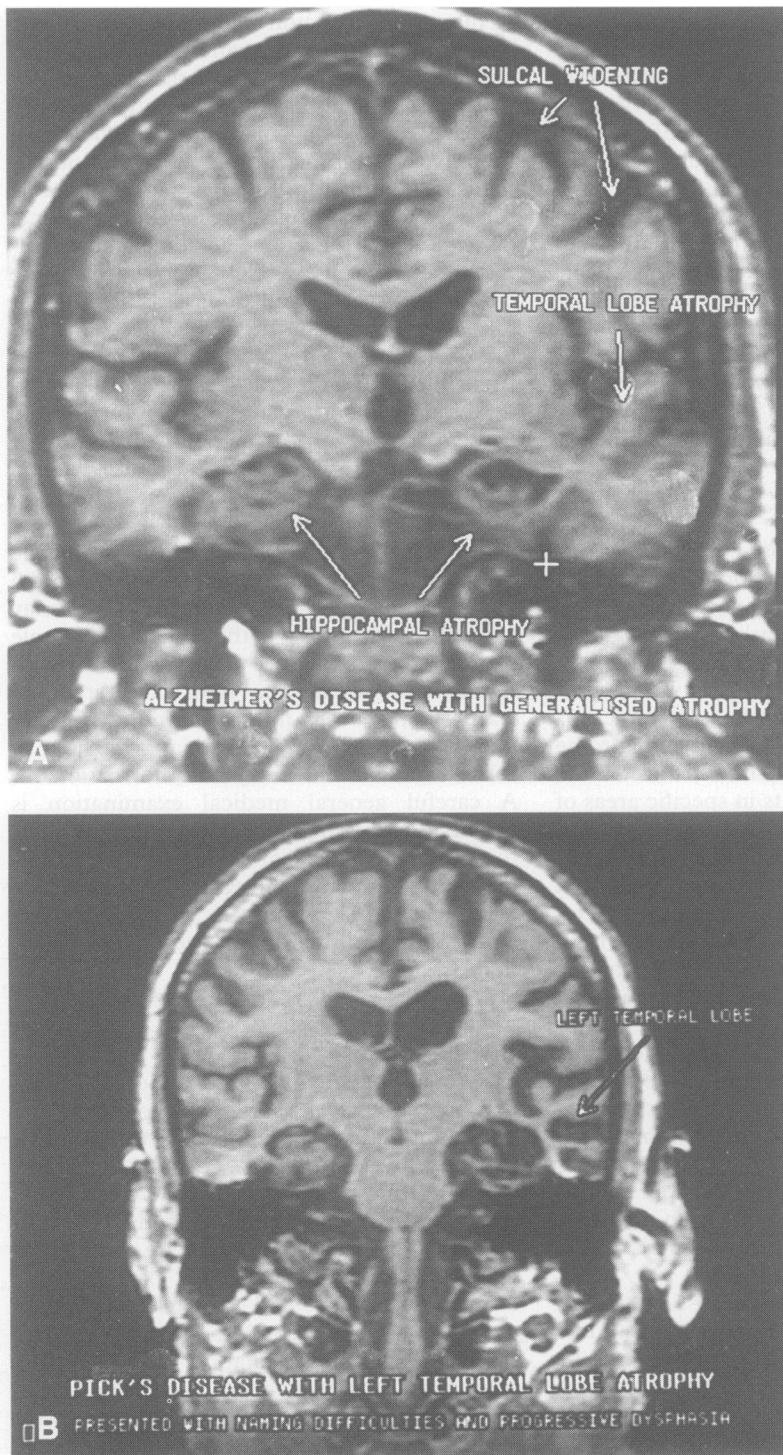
(A) MRI showing bilateral hippocampal and temporal lobe atrophy in a case of Alzheimer's disease. (B) MRI showing asymmetric anterior hippocampal, amygdala, and temporal lobe atrophy in a case of Pick's disease (courtesy of Dr N Fox, St Mary's Hospital, London).
